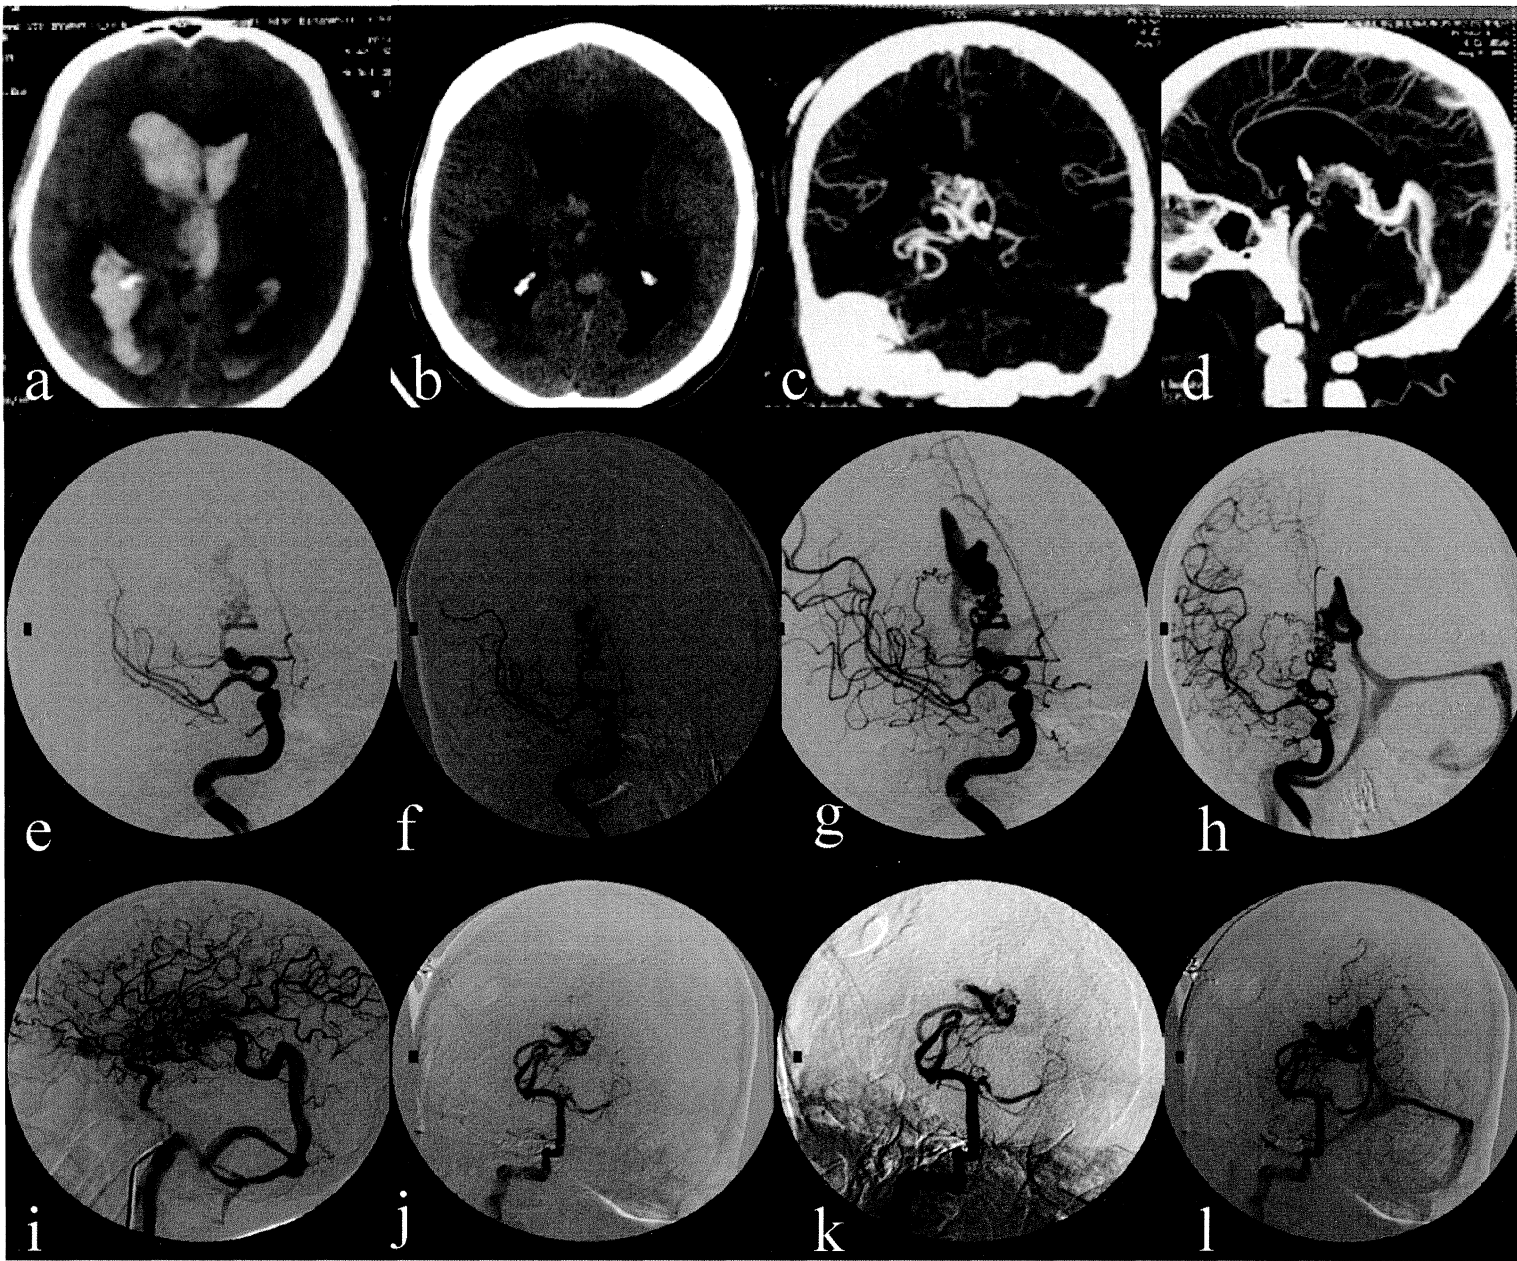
42 year old gentleman presented with sudden onset of headache, vomiting and loss of consciousness, CT (a, b) revealed IVH, CTA (c, d) and DSA (e – l) revealed a small compact choroidal AVM fed by anterior choroidal, medial and lateral posterior choroidal with deep venous drainage (falcine sinus). Note the venous aneurysm at the origin of the draining vein and its subsequent ectatic course.
